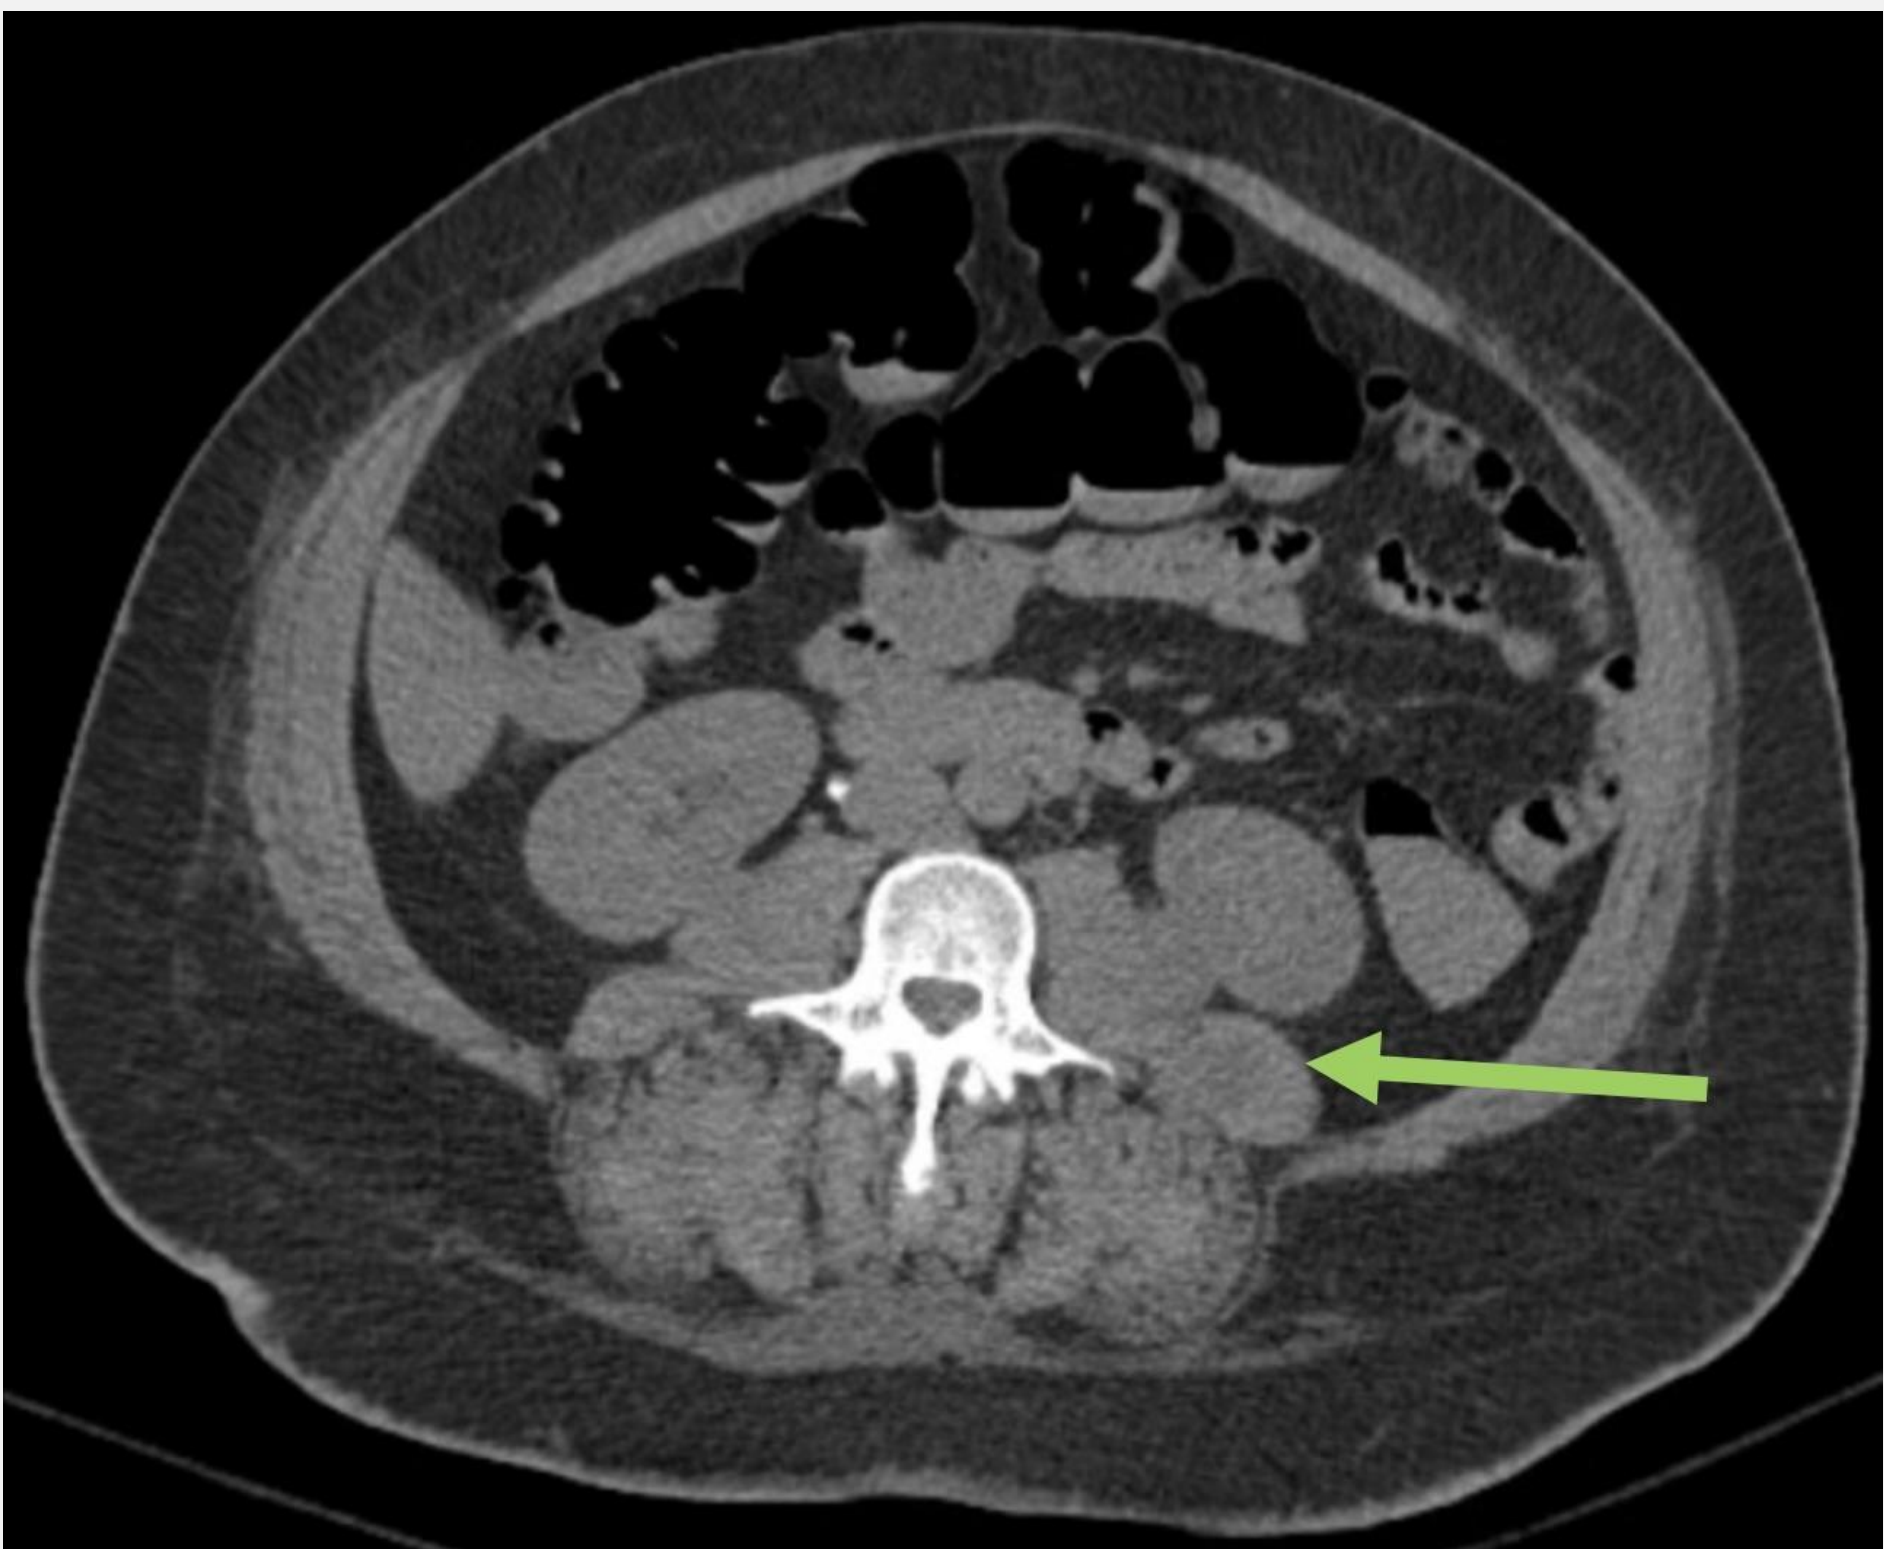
CT Abdomen and Pelvis
